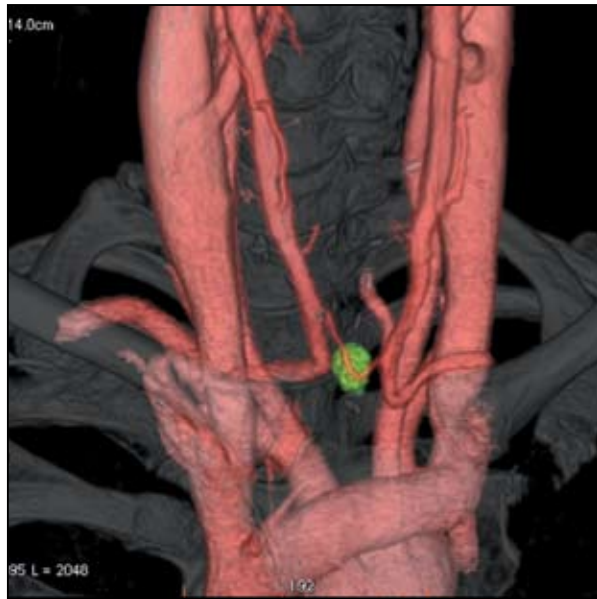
Volume rendered post-contrast CT image demonstrating the parathyroid adenoma (green) relative to the adjacent cervical and upper thoracic vascular and skeletal anatomy.
